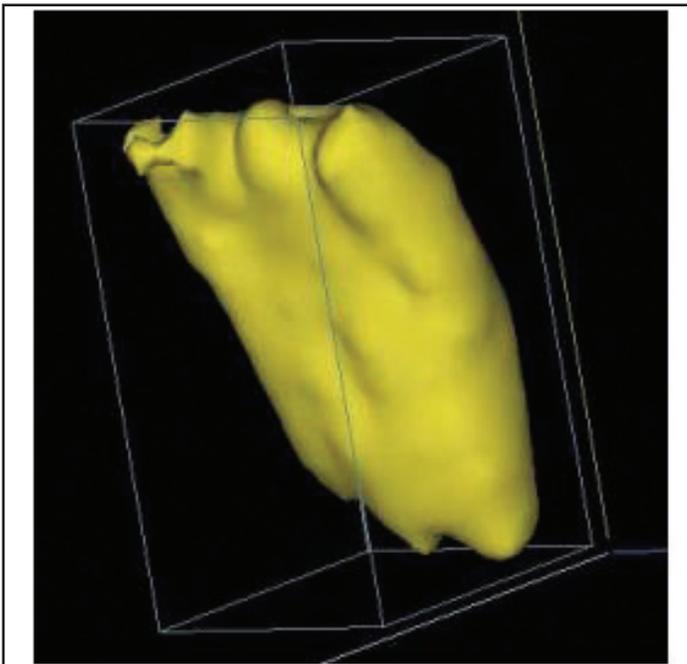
3-Dimensional volumetric magnetic resonance imaging reconstruction of the tongue.
